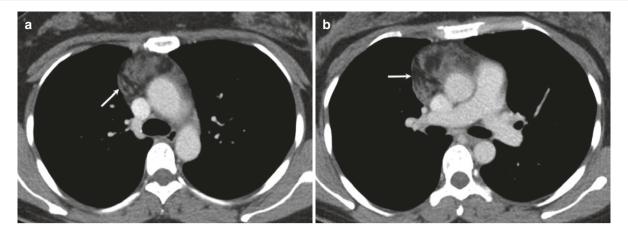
31-year-old woman with thymolipoma. (a, b) Axial CT images show fat density mass (arrow) with whorls of the soft tissue component in the anterior mediastinum
